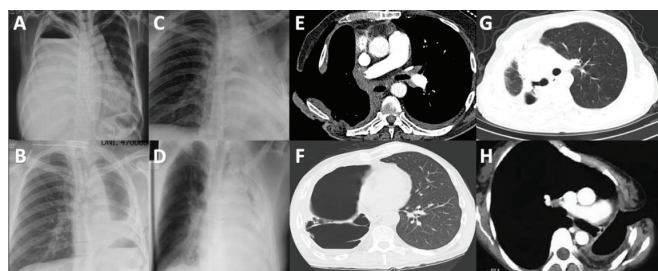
Thoracic radiographs showing various presentations of BPF, including postoperative empyema and collection (A-D), thoracic CT scans show BPF with the presence of postoperative collections and others with thoracic windows (E-H).
